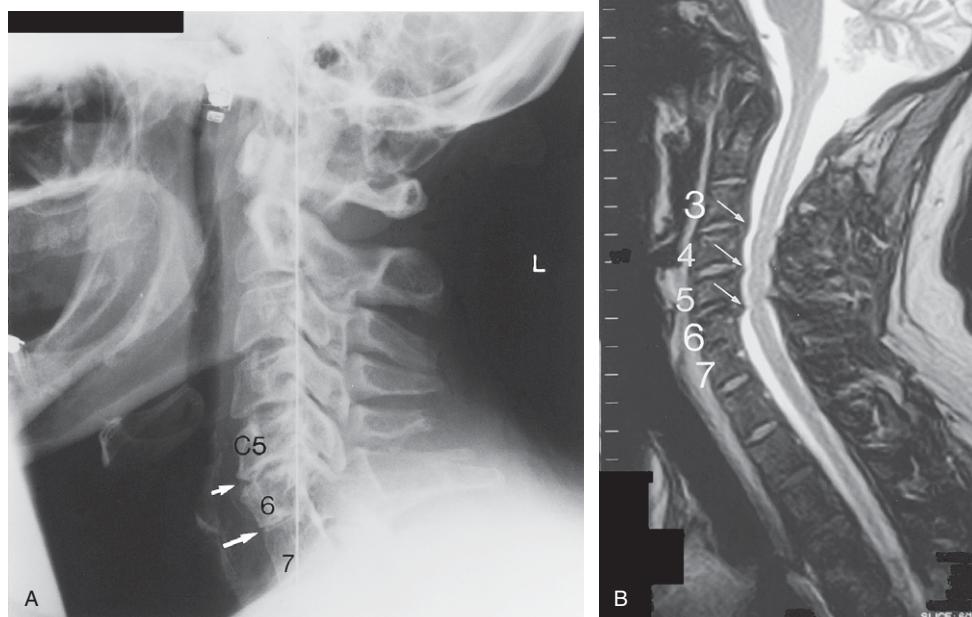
(A) Cervical spine lateral plain X-ray image showing the disc space narrowing at C5–6 (small white arrow) and the partial congenital ‘block vertebra’ at C6–7 (large white arrow). Note the angulation in the cervical spine contour at the C5–6 level which is clearly shown in relation to the vertical plumb line. L shows that the left side of the patient was against the X-ray bucky. (B) Cervical spine MRI sagittal T2-weighted image showing degenerative changes at the C3–4, C4–5 and C5–6 levels (particularly at the C5–6 level) (arrows) with disc/osteophyte impression on the dural tube at these levels with borderline canal stenosis at the C5–6 level. The vertebral bodies have been labelled 3, 4, 5, 6, 7 just to their left side so as not to obliterate the vertebral body with a numeral. Note the partial developmental fusion of the C6 and 7 vertebral bodies.
